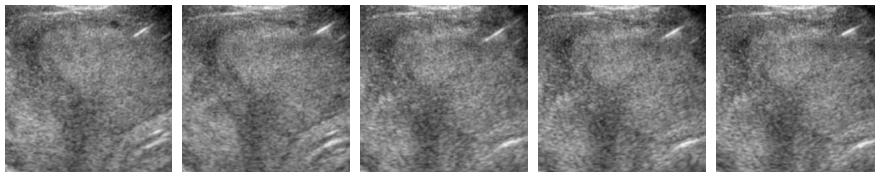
Images from left to right are 5 sample frames among total 20 frames of ultrasound images during Phase I.
